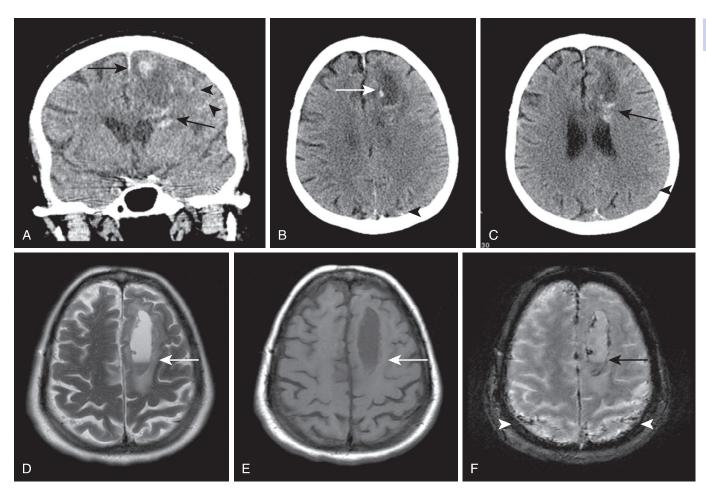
Sources of confusion—superimposed blood products of differing ages and hemorrhagic fluid levels. A patient on anticoagulation with a prior left frontal parenchymal hematoma and known subacute left frontal hemorrhagic cavity presents after an acute exacerbation. Coronal (A) and axial (B and C) computed tomography images at the time of the acute exacerbation demonstrate a hypodense left frontal hemorrhagic cavity with peripheral areas of hyperdense acute hemorrhage (arrows). There are also foci of acute subarachnoid hemorrhage (arrowheads). Axial T2 (D), axial T1 (E), and axial gradient echo (F) magnetic resonance imaging (MRI) images of the brain performed on the same day demonstrate a hemorrhagic fluid level within the subacute hemorrhagic cavity. Without the presence of an appropriate history, and considering the presence of multiple confounding factors, it would be difficult to predict the age of this hemorrhage based on the MRI signal characteristics alone.
